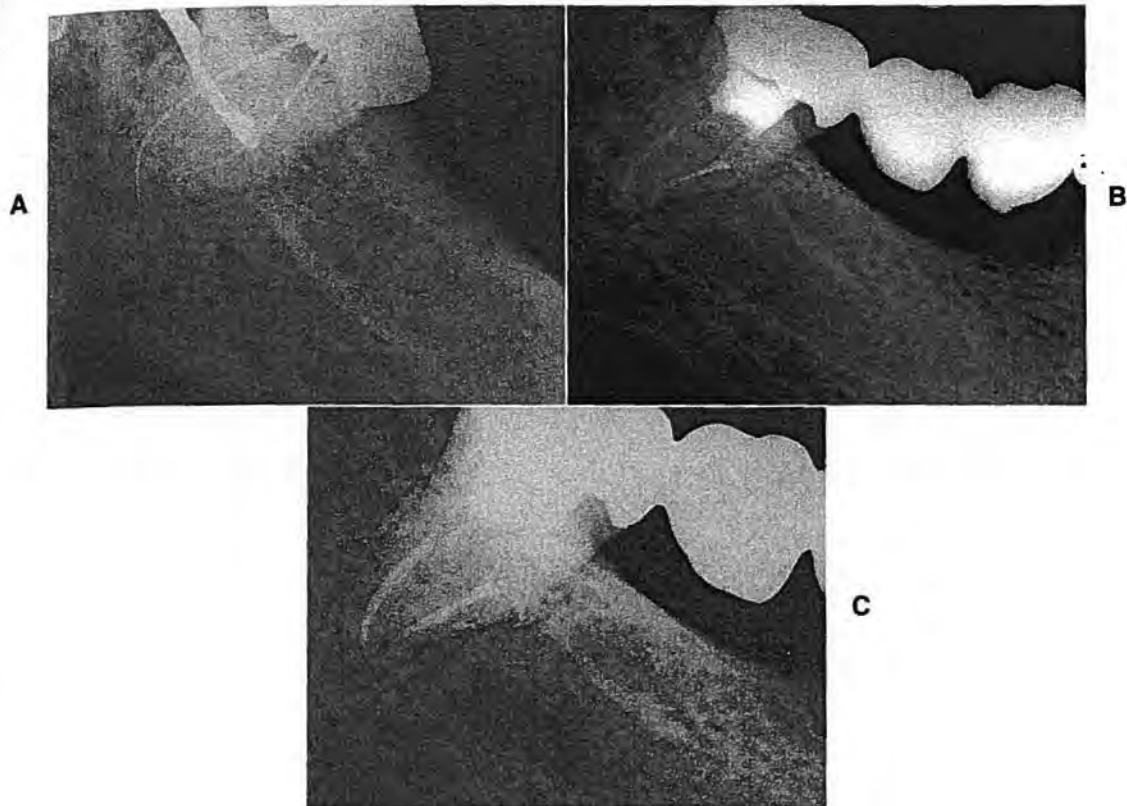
A, Files in place in mandibular second molar, extremely curved distal canal with elbow approximately 2 mm from apex. Compare to Figure 5-38 in which elbow was approximately 7 mm from the apex. B, Canals filled with laterally condensed gutta-percha and Wach's paste. Note how the curvature in the distal canal was maintained by careful use of customized files. C, Two years after completion of treatment, normal periapical areas maintained. (Restoration by Dr. Steve Labkon, Kenilworth, Ill.)
